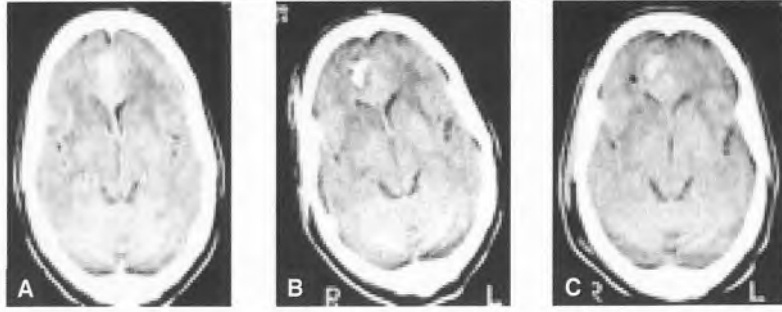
Axial CT scan showing the faintly enhancing lesion in the medial right frontal lobe (a); the site of the first stereotactic biopsy was clearly incorrect, as shown by the small haematoma anterolateral to the mass, and the second biopsy was even more lateral (c). A CT scan was not requested after the third biopsy.
